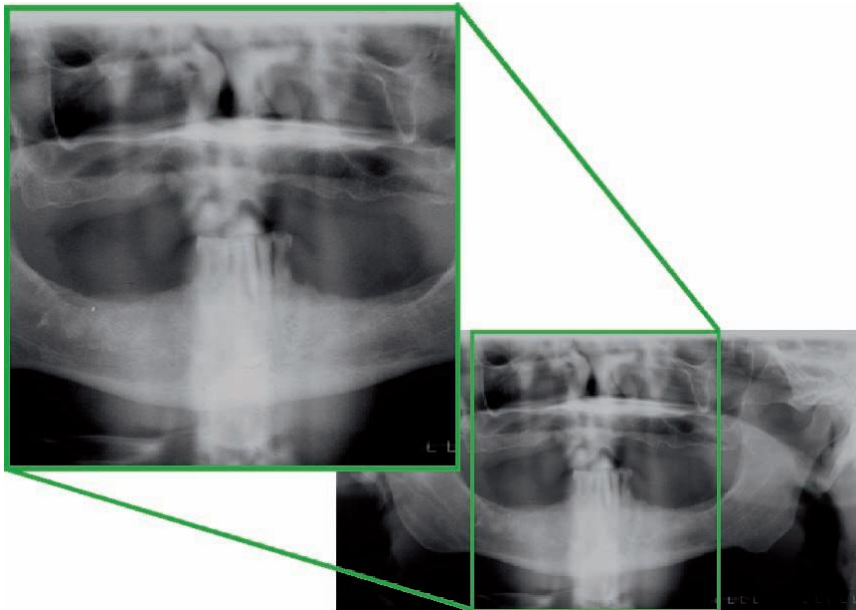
Detail of panoramic radiograph showing how the shadow of the spine can obscure detail of the mandibular anterior teeth if the patient's neck is not kept erect during panoramic radiography
